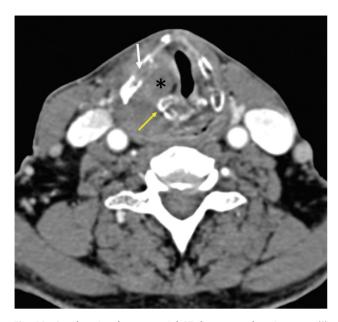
Cartilage involvement-axial CT shows an enhancing mass (\*) involving the right true cord, invading the thyroid cartilage on the right side (white arrow) and encasing the right arytenoid cartilage (vellow arrow).
